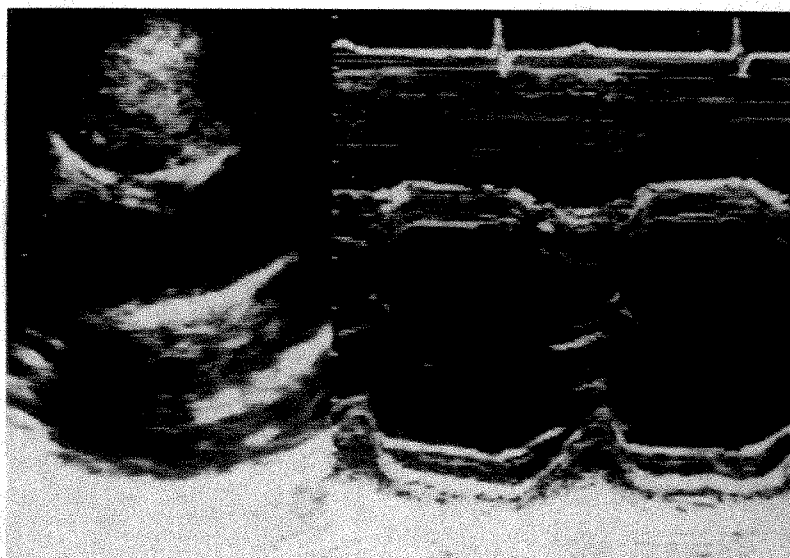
Two-dimensional (left) and M-mode echocardiogram (right) of case number 1 taken immediately after aspiration of pericardial fluid. The pericardial effusion disappeared. Wall thickness returned to normal (ventricular septal diastolic thickness 10 mm and posterior wall thickness 8 mm). Distance between dots is 10 mm.
